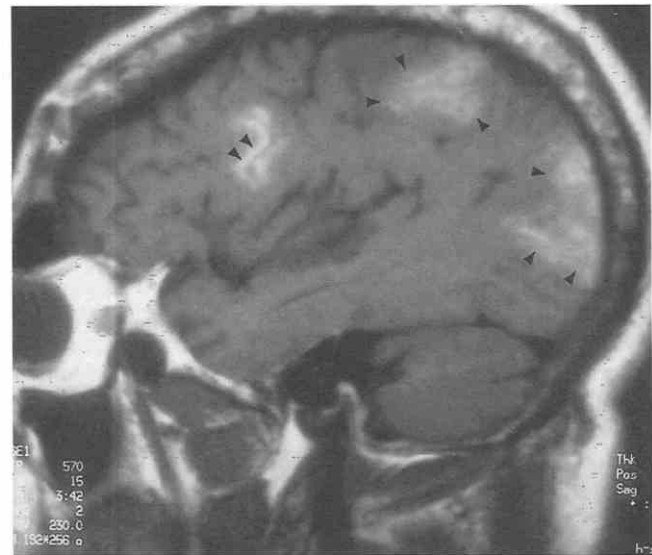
Superior sagittal sinus thrombosis. A, T1-weighted sagittal image (unenhanced) shows increased signal in the superior sagittal sinus (*arrows*). B, T2-weighted axial image shows subcortical decreased signal (*black arrows*), surrounded by increased signal edema (*small arrows*). The subcortical location of hemorrhage is characteristic of venous infarction.
